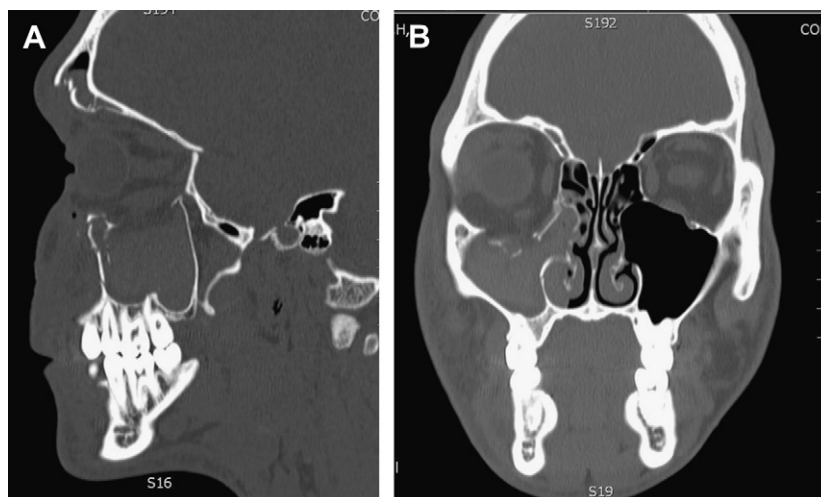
CT imaging in the evaluation of orbital fractures. (A) Sagittal view showing posterior extent of orbital floor fracture. (B) Coronal view showing inferior displacement of right orbital floor with increased orbital volume.
